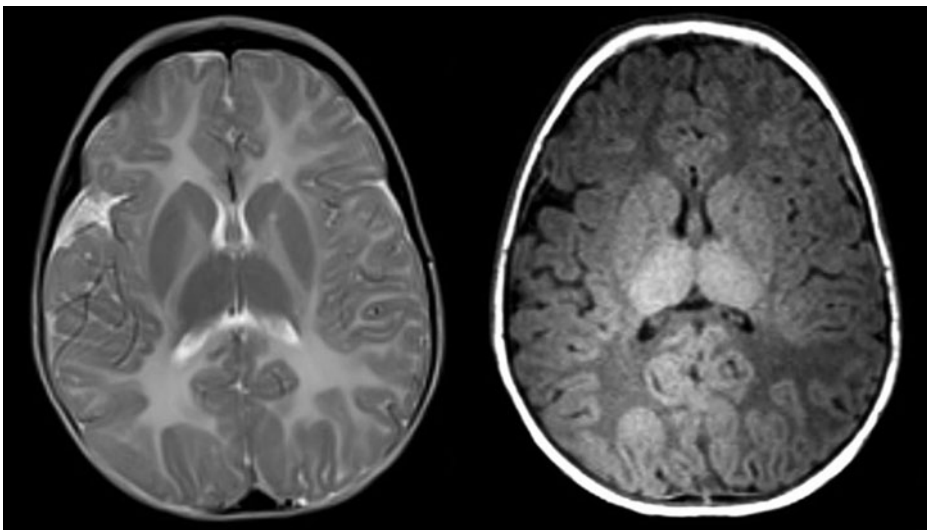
A 12-month-old boy with Pelizaeus-Merzbacher disease. T2 (left) and T1-MPR (right) axial sequences from a brain MRI show diffuse white matter signal intensity abnormalities with no evidence of myelination on the T1-MPR or T2 weighted images. There is bilateral, symmetric abnormal T2/FLAIR signal hyperintensity in the internal and external capsules.
